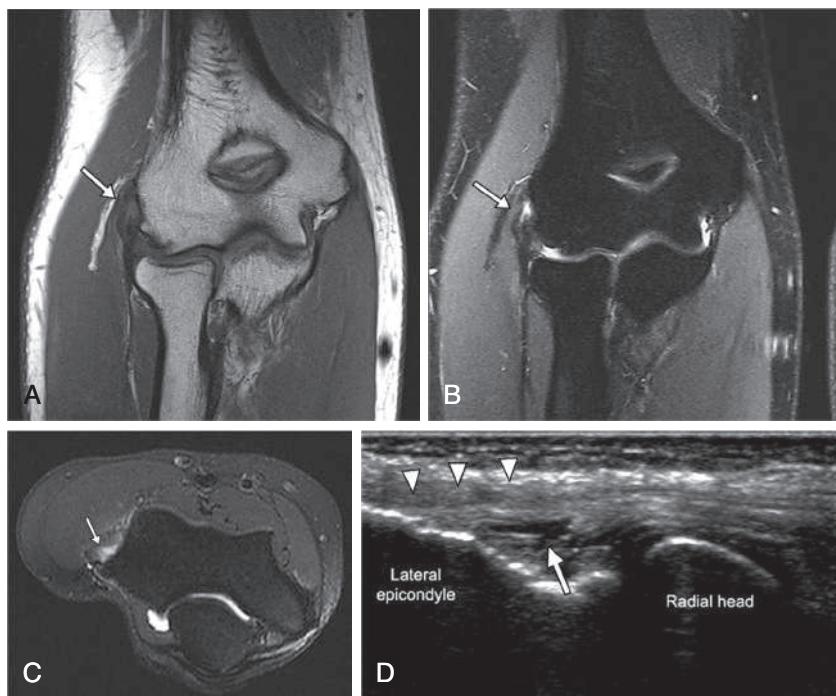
A 22-yr-old tennis player with persistent lateral elbow pain despite 3 months of physical therapy. A, Coronal T1 sequence shows thickening and intermediate signal in the common extensor tendon (CET; arrow). B, Coronal T2 fat suppression (FS) (CET; arrow) and (C) axial proton density FS sequences reveal fluid signal within the CET and discontinuity of tendon fibers, consistent with a partial-thickness tear (CET; arrow). D, Corresponding long axis ultrasound image shows an anechoic fluid cleft (arrow) in the undersurface of the CET (arrowheads). (From Gustas CN, Lee KS. Current imaging concepts and image-guided treatments for the injured thrower's elbow. Radiol Clin N Am. 2016;54[5]:817–839. Fig. 2.)
